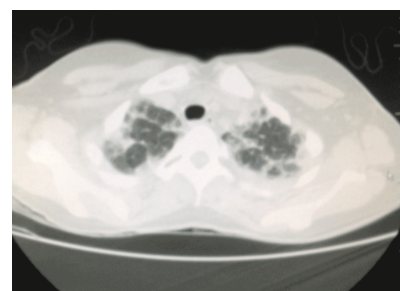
Admission CT upper lobe
